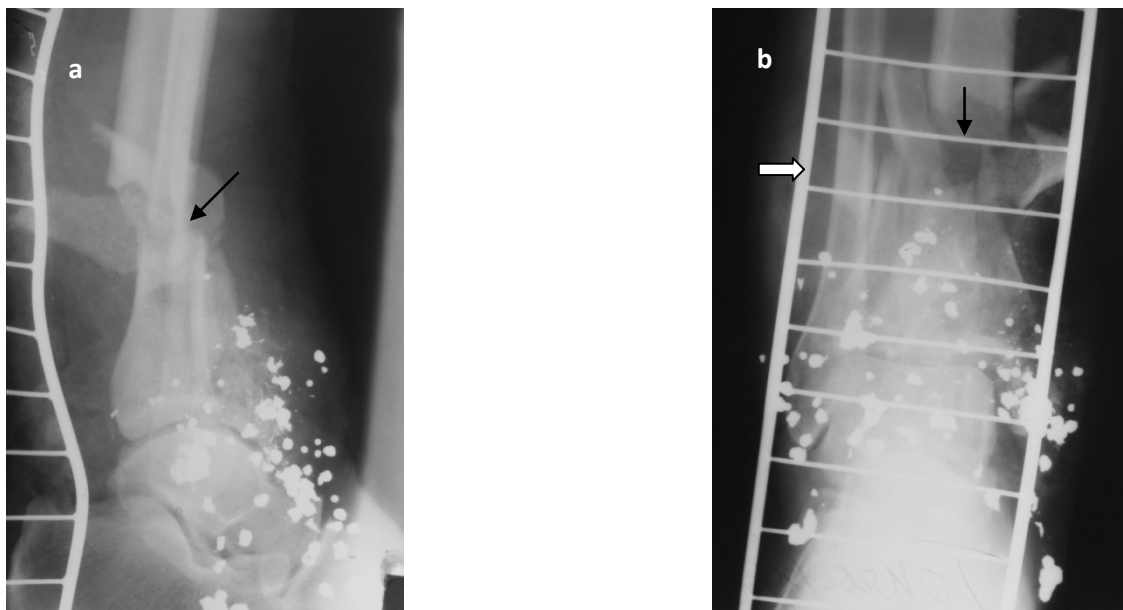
Radiographs of the shin in lateral (a) and direct (b) projections. In the area of the ankle joint in both projections there are multiple small the round high-intensity foreign bodies (gun shot). Fracture lines in distal thirds of tibia and fibula diaphyses (black arrows), and also in distal metaphysis of the tibia. Numerous bone splinters in the area of the tibia lesion. A wire transport splint (a figured arrow). Fire fractures of shin bones: multisplintered tibia and transverse fibula fractures
